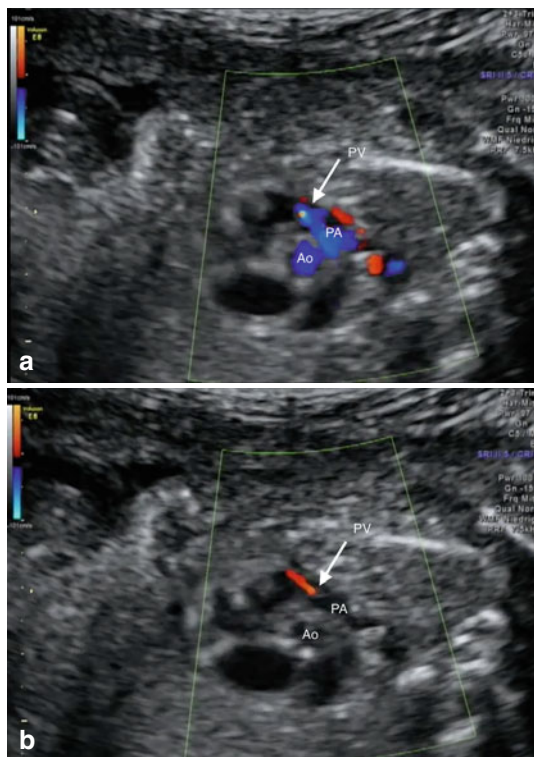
Color Doppler after a successful pulmonary valvuloplasty: (a) picture in systole (note the blue color across the pulmonary valve indicating now antegrade flow from the right ventricle into the pulmonary artery) and (b) picture in diastole (note the red pulmonary regurgitation jet back into the right ventricle indicating some damage of the pulmonary valve after valvuloplasty). *Ao* aorta, *PA* pulmonary artery, *PV* pulmonary valve
